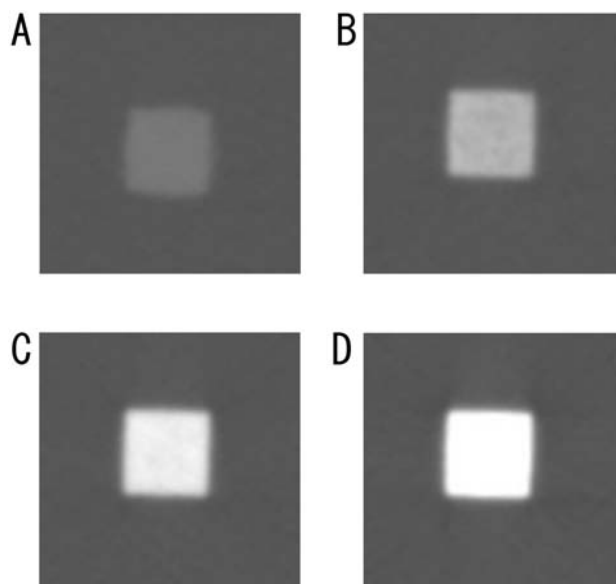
CT images of HA blocks
